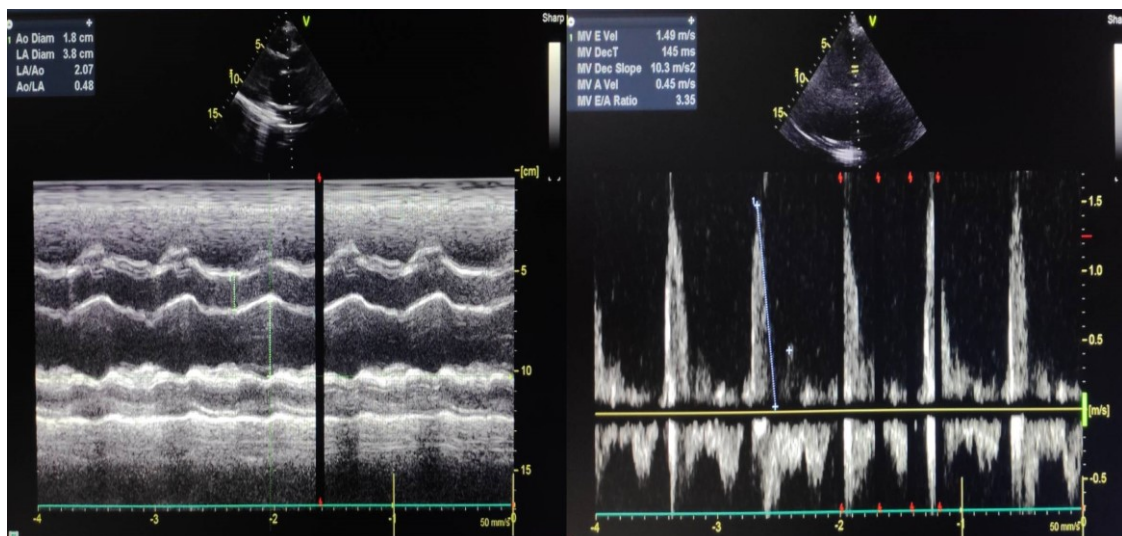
Echocardiography showing abnormality of LV diastolic function grade 3 and a mild concentric left ventricle hypertrophy
